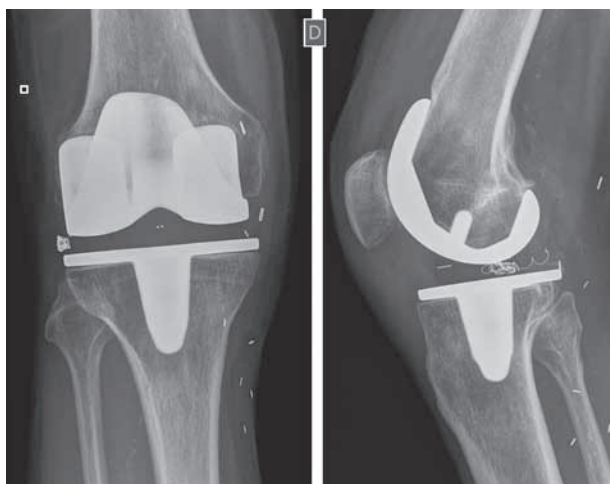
Anteroposterior and lateral radiographs showing clips from the first haemostatic intervention and coil embolization of the superior lateral branch of the popliteal artery (case 1).
